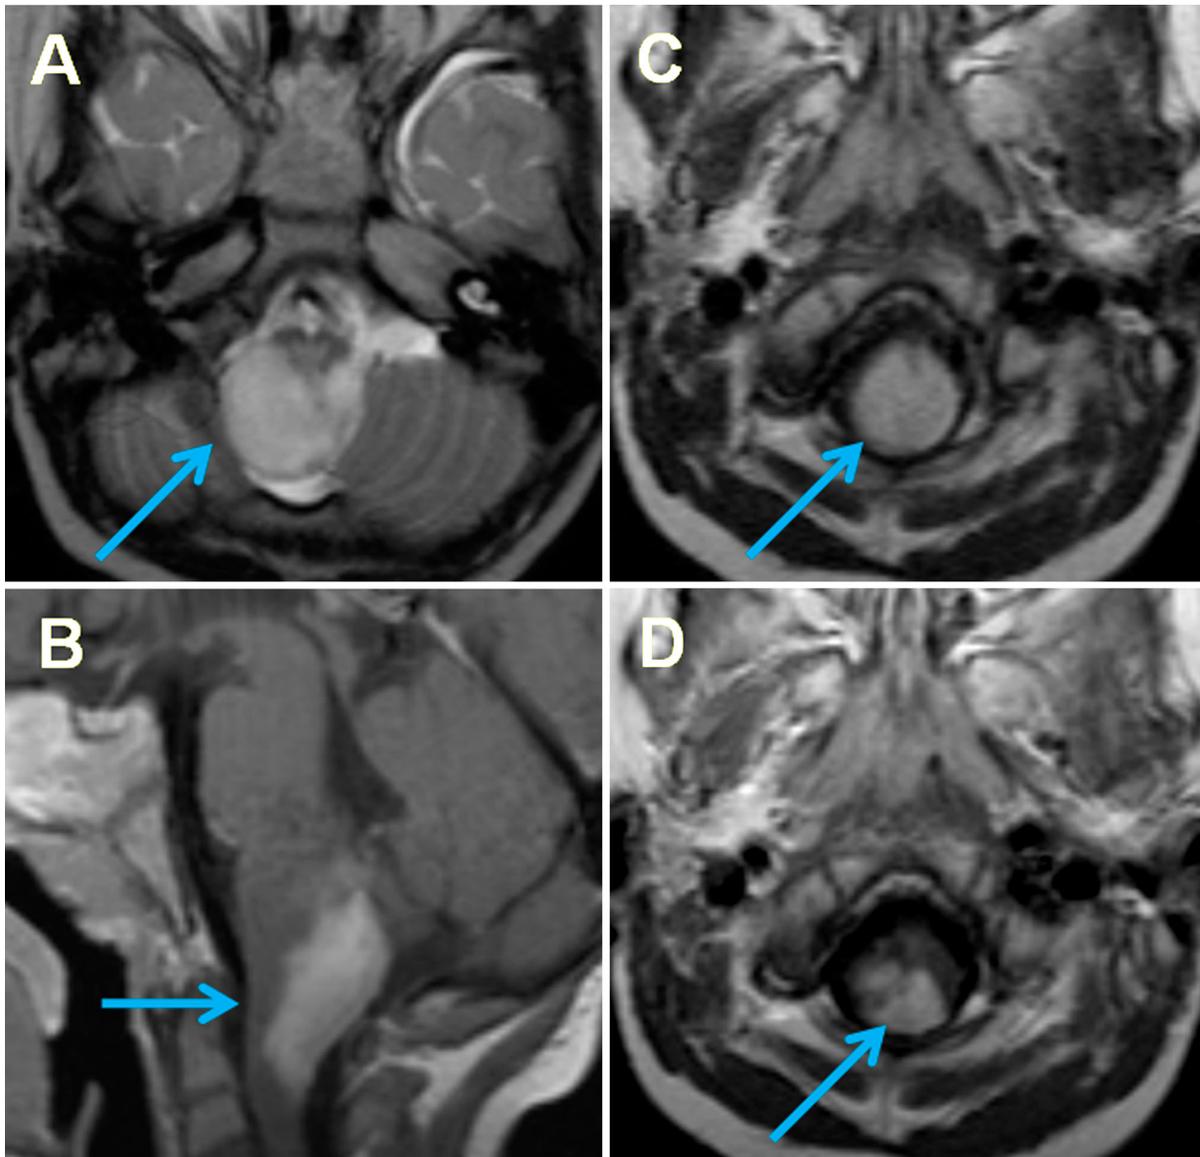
PF GG in a 3 year old boy with soft voice and dysphagia. a T2-weighted axial image demonstrates a hyperintense expansile mass at the pontomedullary junction. b T1-weighted post contrast sagittal image shows characteristic dorsal predominant “paintbrush”
